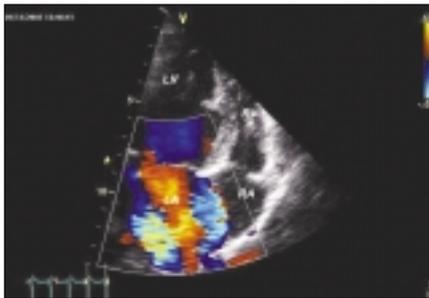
Color Doppler echocardiography apical long-axis view of two eccentric regurgitant jets
